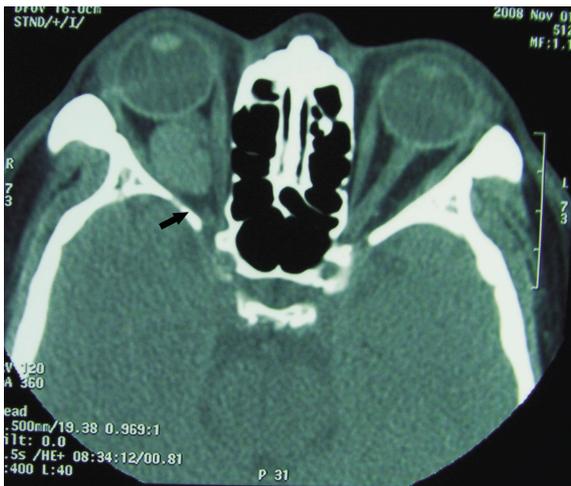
Transparent triangle structure (black arrow) revealed by CT between CH and the orbital apex in case 1 with severe adhesion
